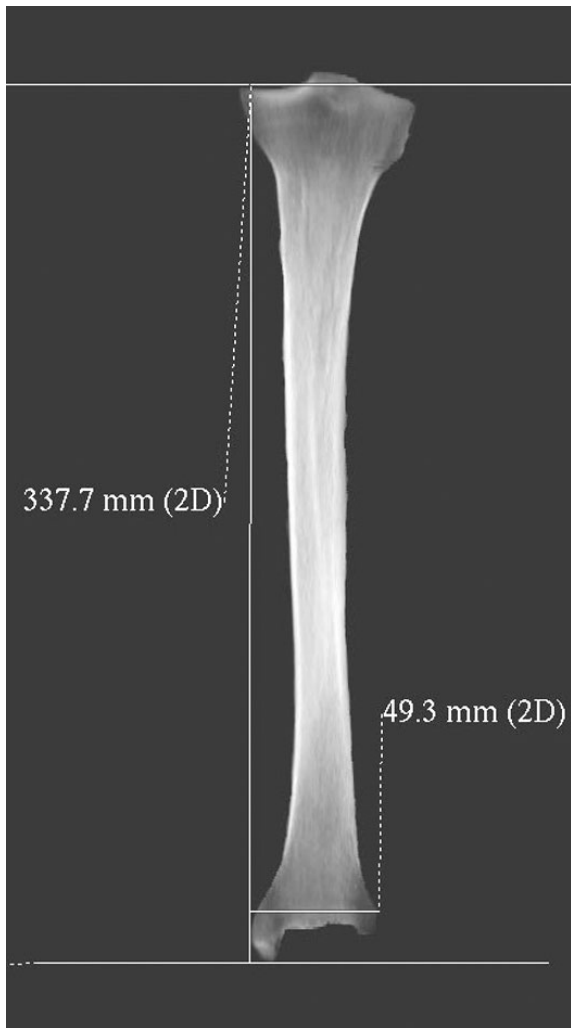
A “transparent bone” image, created from a 3D volume rendered reconstruction of CT image data, demonstrating the landmarks for tibial measurements.
